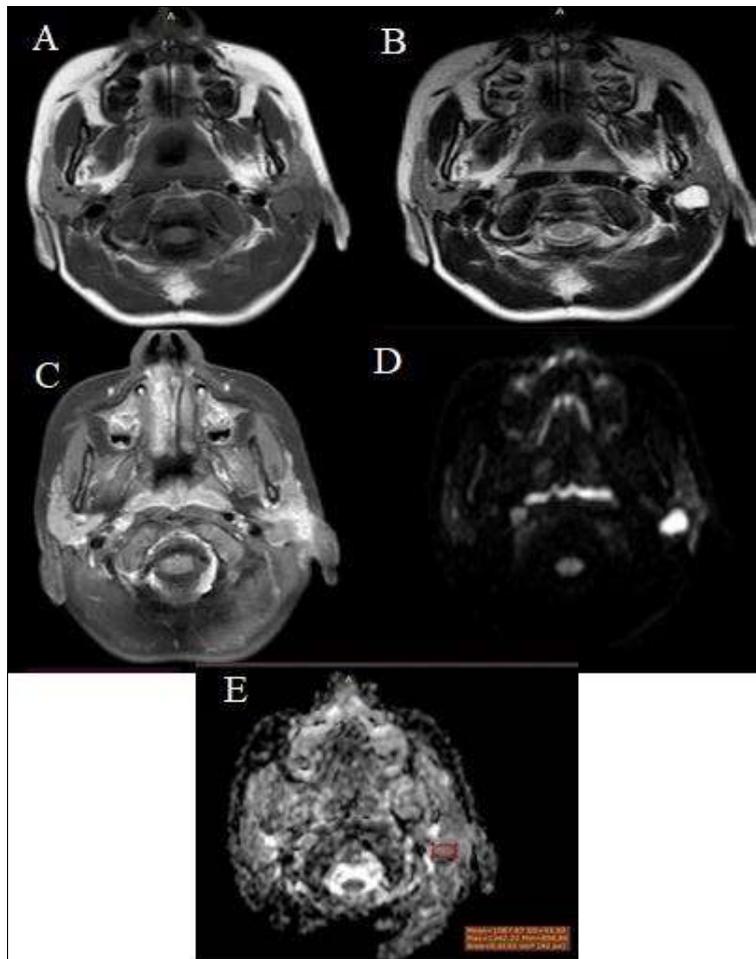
MRI findings were: (A) a well-defined cystic lesion related to Superficial lobe of left parotid gland appear low signal intensity at T₁WI, (B) high signal intensity at T₂WI, (C) peripheral enhancement at fat suppressed T₁ with contrast, (D) seen restricted on DWI, (E) with ADC value estimated to be $1.087 \times 10^{-3} \text{ mm}^2/\text{s}$.
